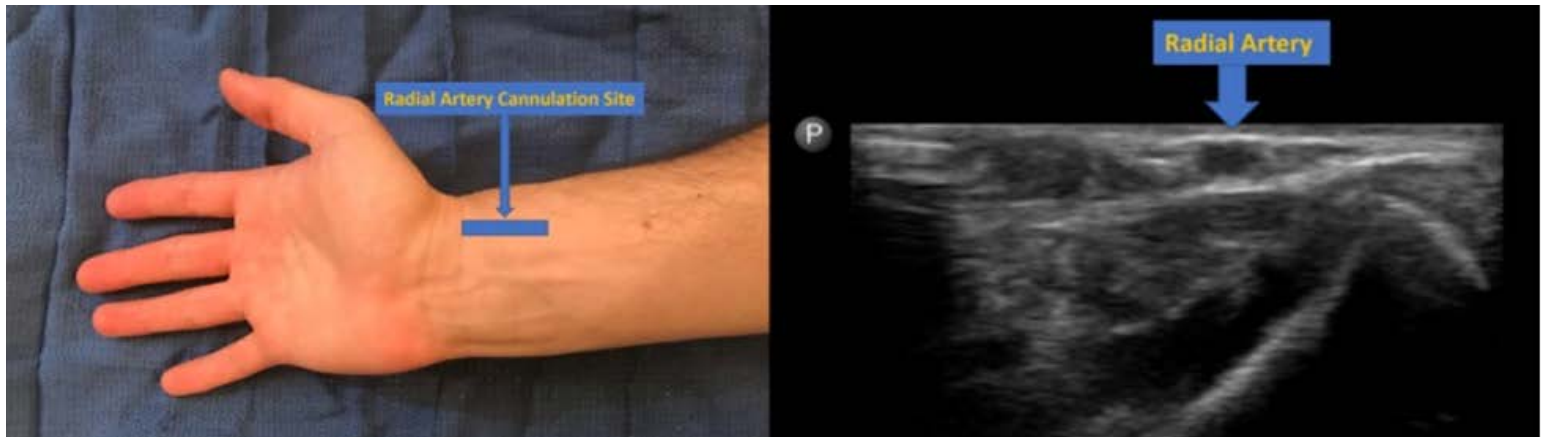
Radial Artery Cannulation Site and Ultrasound Image
